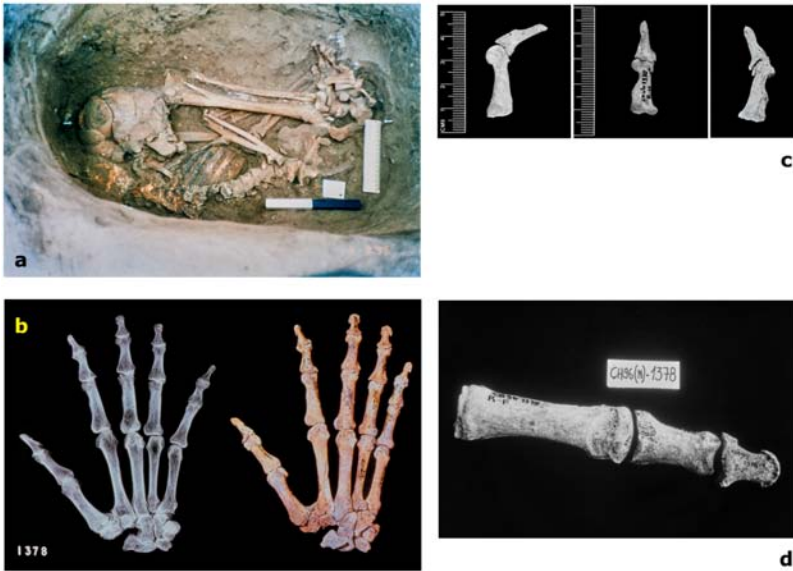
Signs of hypermobility on joints of disarticulated skeleton of old male from Çatalhöyük, Turkey: a) crouched burial of CH96.Sk1378 in situ; b) dorsal and radiographic views of reassembled hand bones; c) phalanges of thumb, index and fifth fingers; d) bones of big toe with imprint of proximal phalanx on first metatarsal. Photos: Photo Studio NHM; Genis Ribe, Çatalhöyük excavations.
